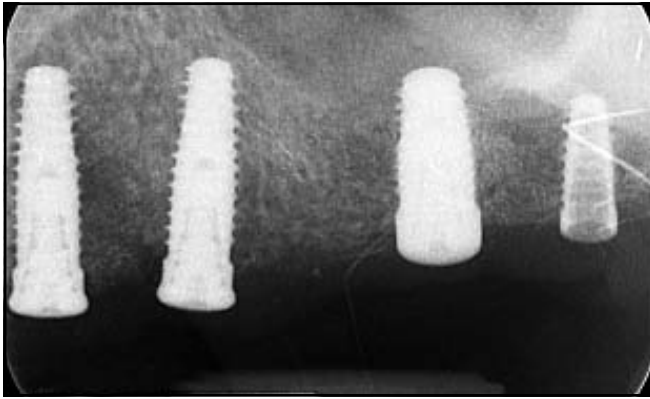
Digital radiograph taken at completion of the surgical procedure. Note the relationship between the implants and the inferior wall of the sinus.
